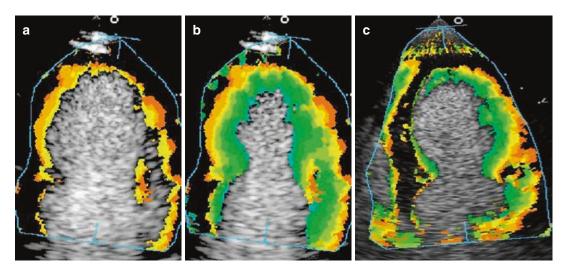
Demonstration of colour kinesis in the apical 4-chamber for automated endocardial tracking. At end-diastole (a) a thin rim of colour delineates the endocardium. (b) There is progressive change in colour depicting
